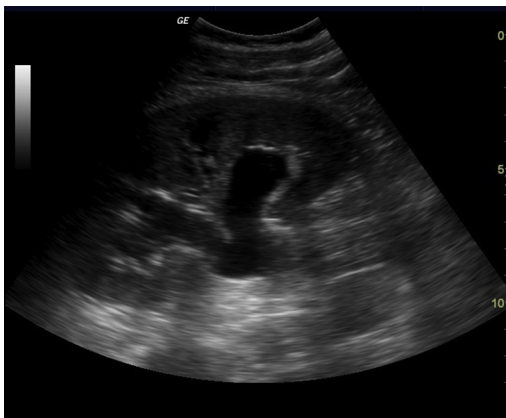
Hydronephrosis shown on a bedside ultrasound. (Courtesy of Michael Stone, MD, Boston, MA.)
